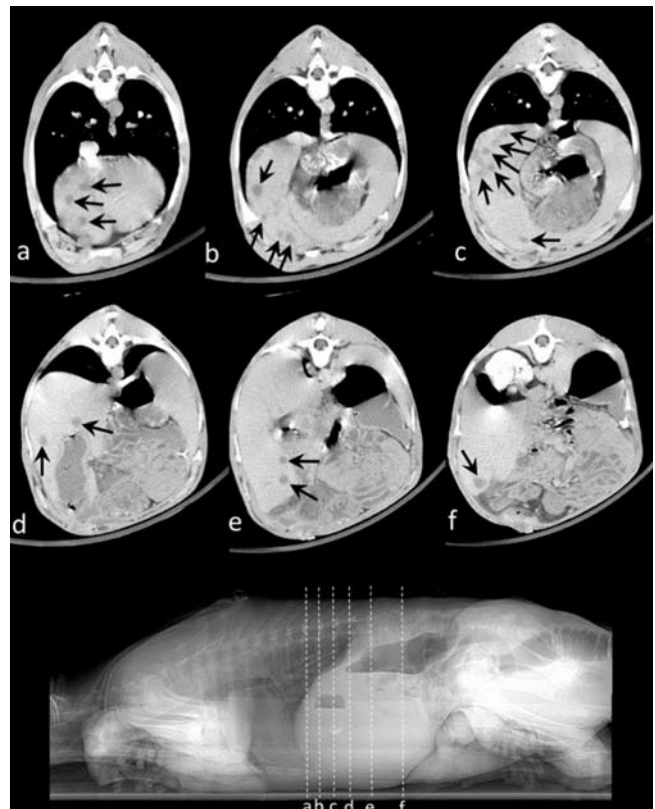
Contrast enhanced computed tomography showed multiple hepatic abscess of case 3. Arrows show the multiple hepatic abscess.
